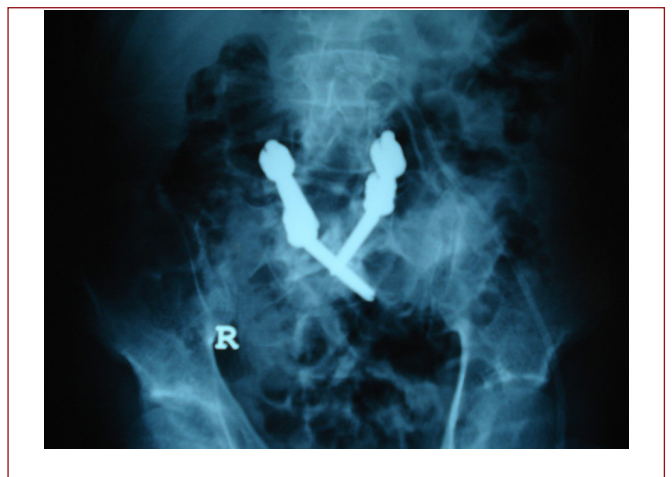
Postoperative AP X-ray, bilateral L4 pedicular screws and S1 pedicular screw on the left side, S1 to L5 transcorporeal screw on the right side.
